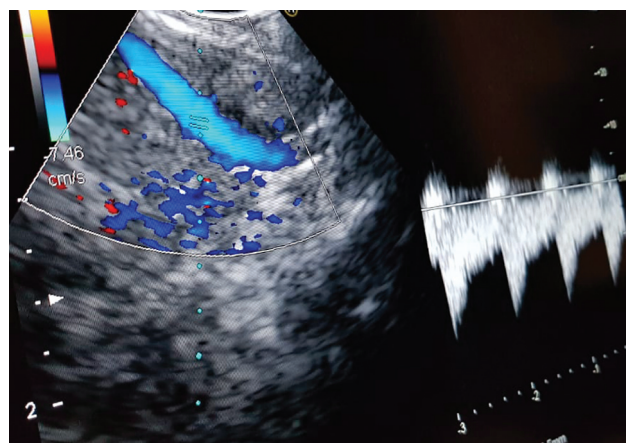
Endobronchial ultrasound (EBUS) with Doppler and spectral waveform showing vessel in close proximity to the mediastinal node.
